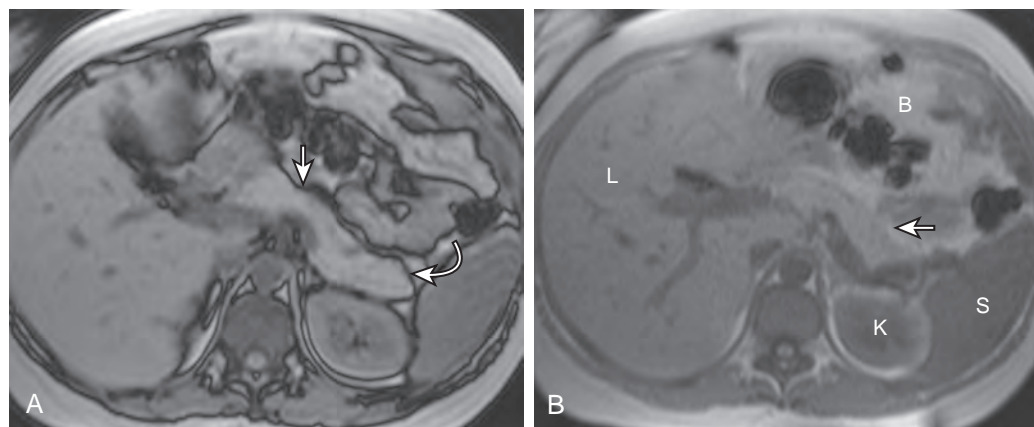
Normal pancreatic anatomy on MRI T1-weighted images. A. T1-weighted out-of-phase gradient-echo image (239/2.4/70) shows the normal appearance of the pancreatic body (arrow) and tail (curved arrow). B. T1-weighted in-phase gradient-echo image (239/4.76/70) similarly shows the pancreas (arrow) without the chemical shift artifact. B, bowel; K, kidney; L, liver; S, spleen.
